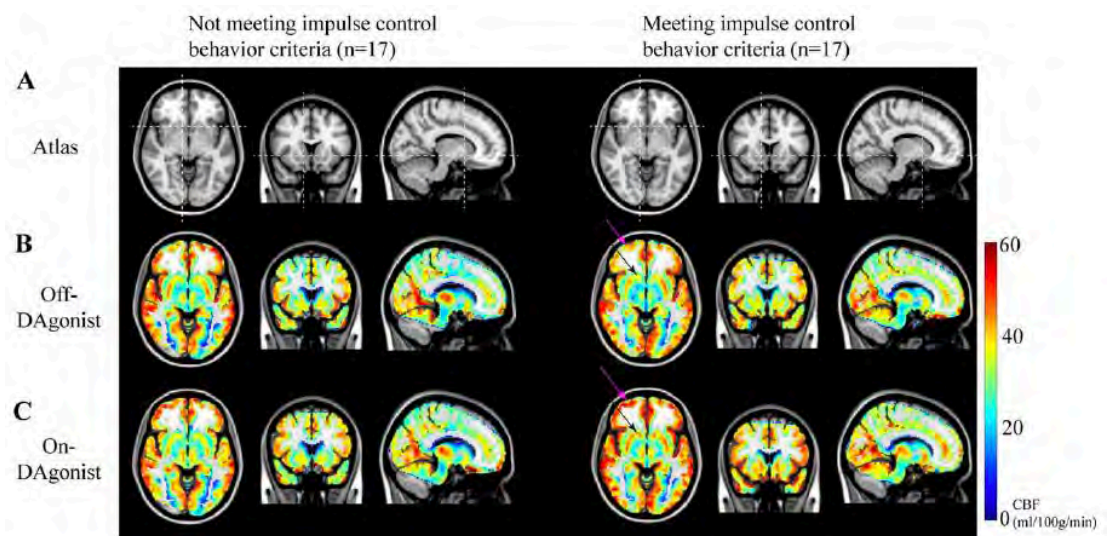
3 CBF response to DA agonist. (A) Orthogonal representation of the 2-mm T1-weighted structural atlas, along with (B) quantitative CBF values in the off-DA agonist and (C) on-DA agonist states for ICB– (left) and ICB+ (right) patients.
